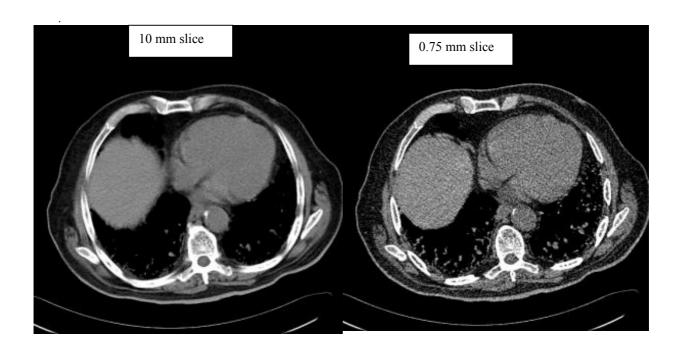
Increased anatomic detail and noise associated with thinner CT slices suggests that they may be less compressible than thicker slices. Both PSNR and the JND techniques support this.
